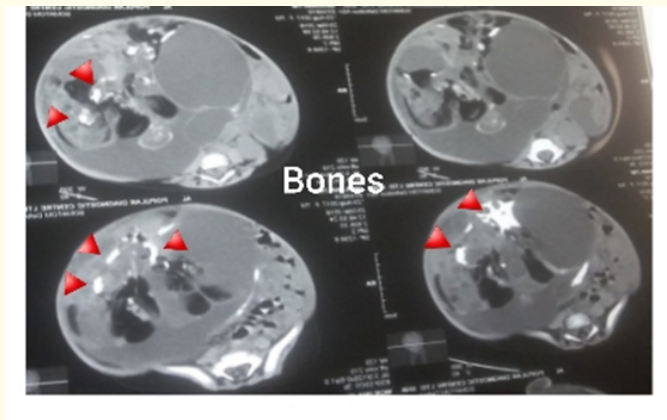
CT scan of Abdomen shows mixed density mass lesion cystic, solid, calcification and fatty component is seen.
